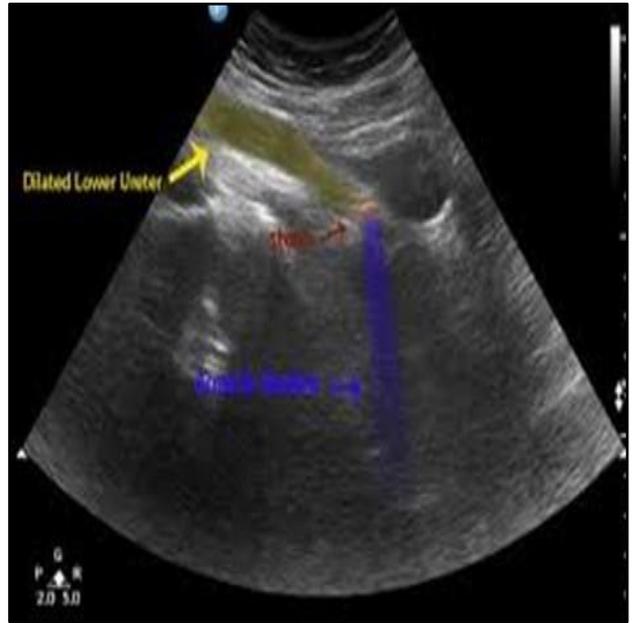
Lower ureter stone on ultrasound scan
